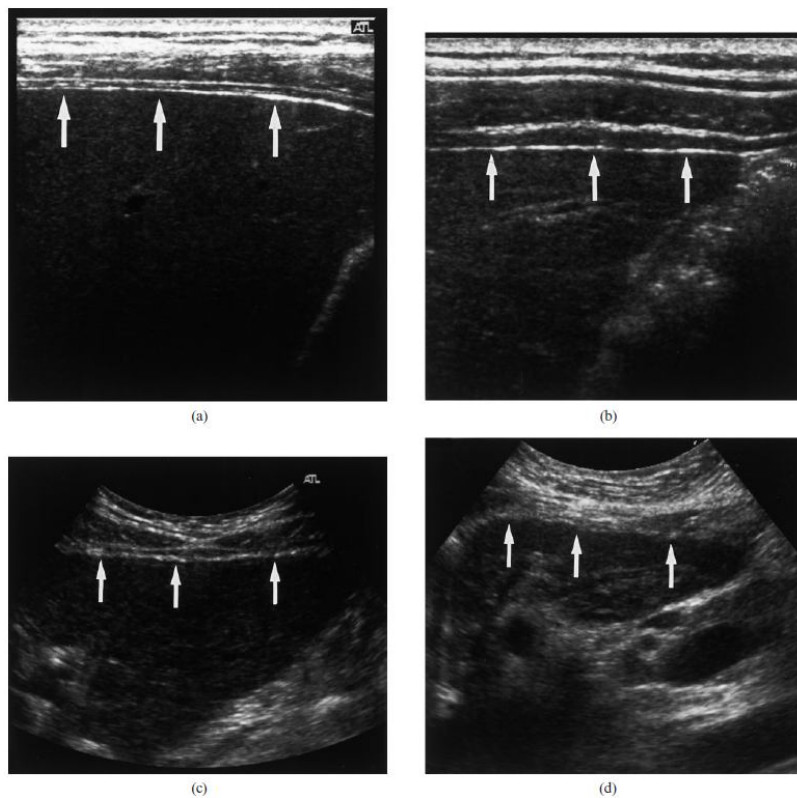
Ultrasound images of the liver surface. (a) and (b) show a smooth and mildly irregular surfaces with a high frequency ultrasound transducer, respectively; (c)
